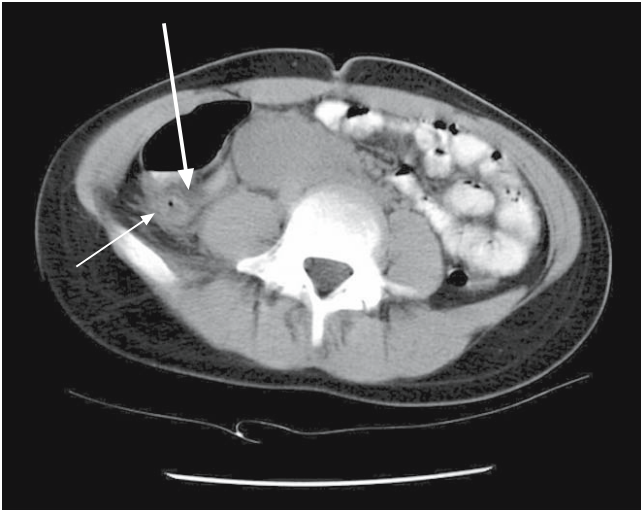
CT scan through the right lower quadrant showing thickened appendix (*thin arrow*) with peri-appendiceal fat infiltration (*thick arrow*) confirming the diagnosis of acute appendicitis
